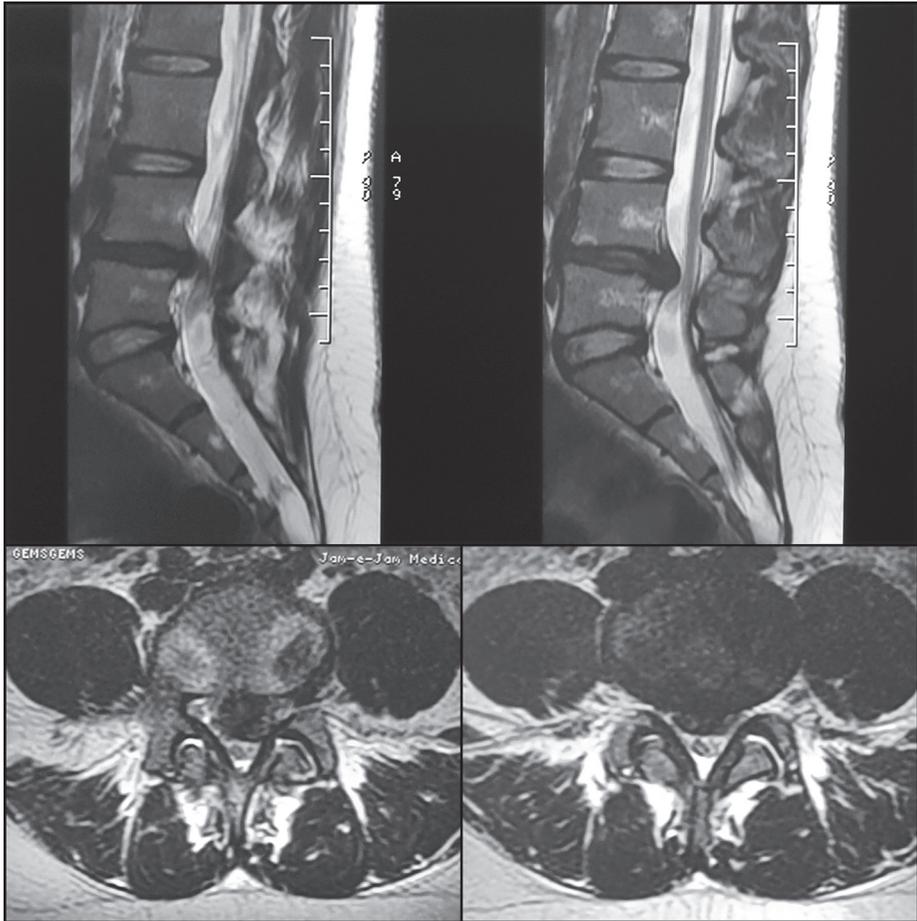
Preoperative T2 weighted sagittal and axial magnetic resonance imaging of lumbar spine showing bulky disk extrusion at L4/L5 level compressing conus medullaris of the tethered cord and exiting roots.
